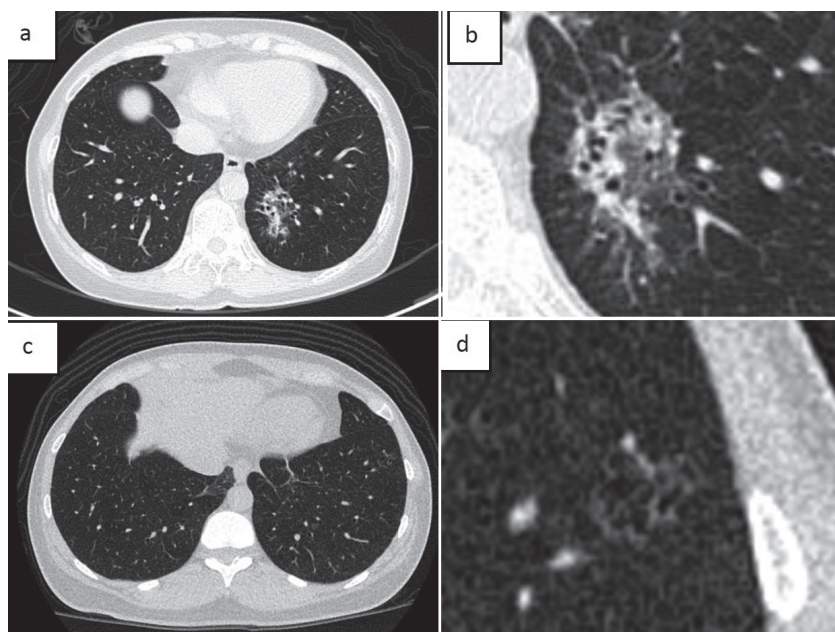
(a) and (b) Computed tomography (CT) scans of case 1, displaying 4 × 3 cm ground-glass opacities with traction bronchiectasis. (c) and (d) Low-dose CT demonstrating a 1.4 cm sub-solid nodule with air-cyst formation at the peripheral left lower lobe of the lung.
